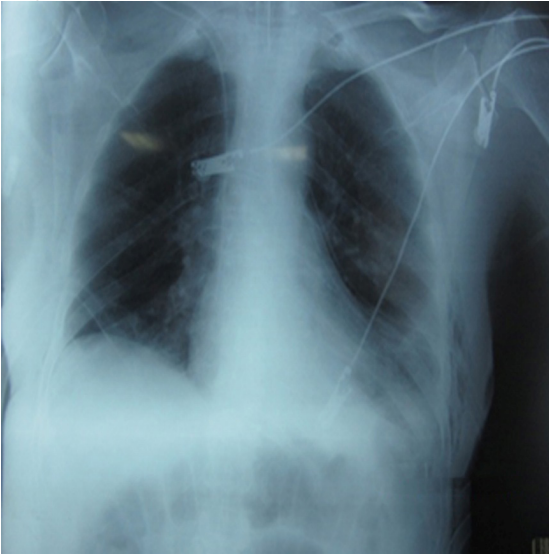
Control Chest X-ray showed reexpansion of both lungs and resolution of SE
